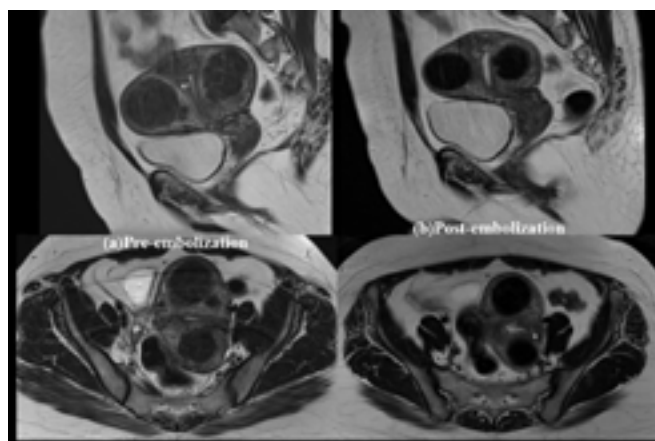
a) Pre-embolization MRI demonstrates enlarged multifibroid uterus with larger subserosal cum intramural fibroids are seen along anterior (FIGO-IV) and posterior wall (FIGO-V) of the uterus causing mild displacement of the endometrium. b) On post-embolization MRI, there is almost 30% of FIGO-IV and 50% of FIGO-V volume reduction achieved.
